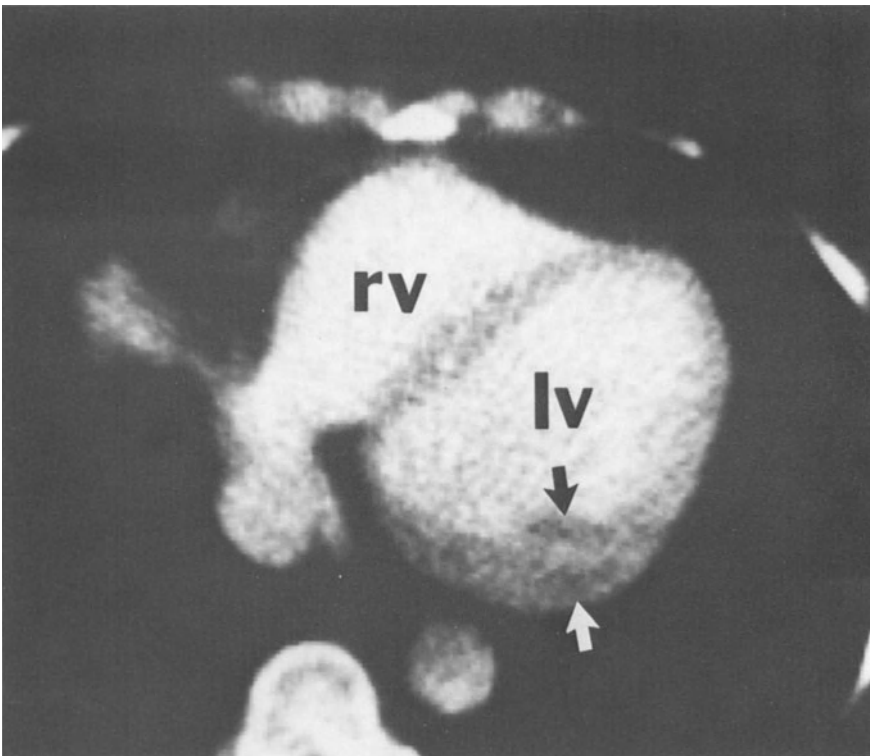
A small subendocardial posterolateral wall myocardial infarction is seen on this CT scan (white arrow). A portion of the lateral papillary muscle is also infarcted (black arrow). LV = left ventricle, RV = right ventricle.
